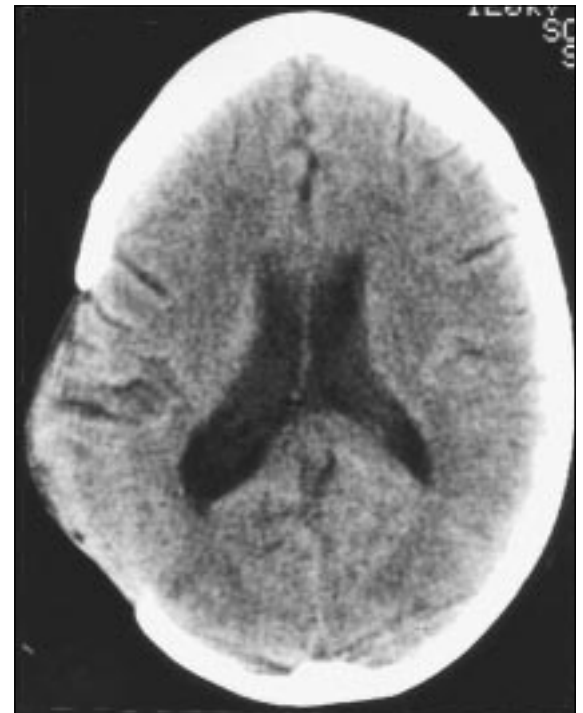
Computed tomogram showing extracranial extrusion of right cerebral hemisphere as result of cerebral oedema. Extrusion is through site of evacuation of previous intracranial haematoma, which was not covered with bone flap after surgery
